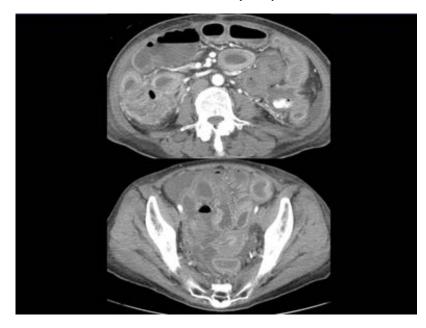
Enhanced computed tomography (CT) after deterioration Enhanced CT showed swelling of the whole bowel with mild ascites without free air.
